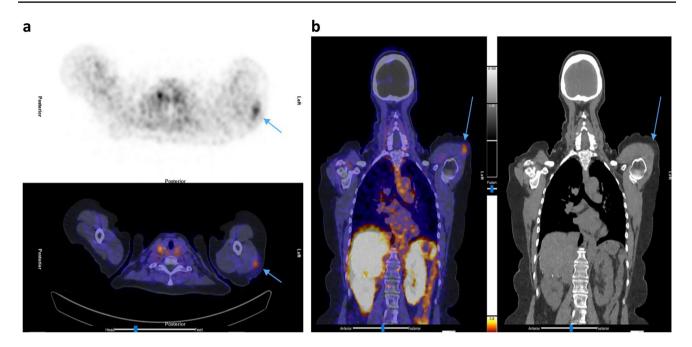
Patient B: [⁶⁸Ga]Ga-DOTA-NOC PET/CT. a Trans axial PET and fused PET/CT showing left deltoid muscle uptake (tip of arrows). b Coronal fused PET/CT, and CT only showing left deltoid uptake (tip of arrows)
